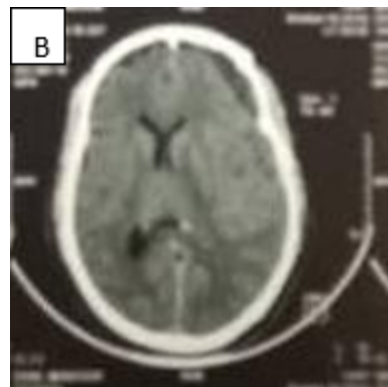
Cerebral CT scan without injection of contrast medium showing with partial resorption of the haematoma at one month of corticosteroid therapy
